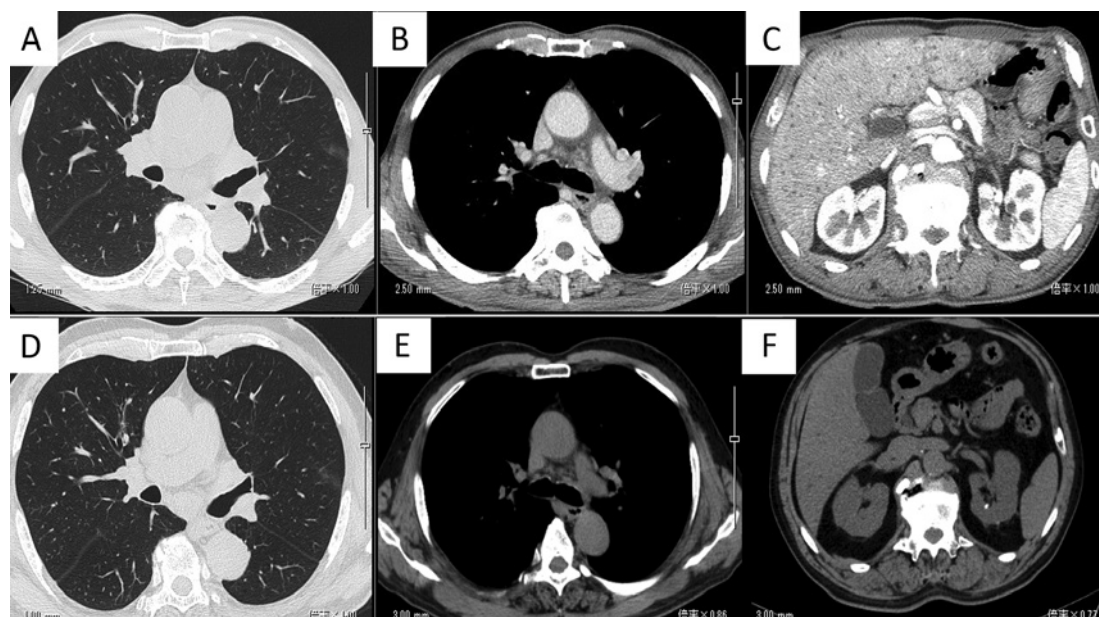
Chest computed tomography scans. A–C Performed on day 468 after the initiation of pembrolizumab. D–F Performed on day 964 after the initiation of pembrolizumab. There was no recurrence of lung adenocarcinoma, and the patient maintained a complete response.
